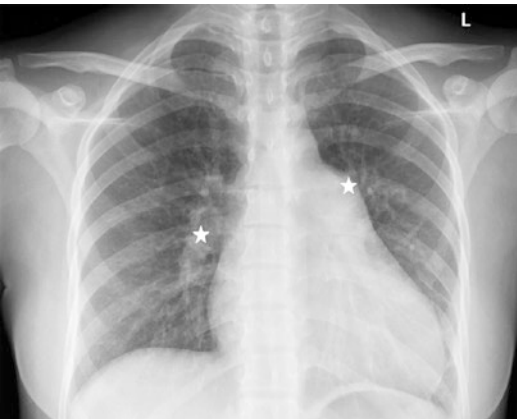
Pulmonary hypertension in a 29-year-old woman with 27 weeks of pregnancy. Chest radiograph reveals dilated pulmonary arteries (stars), and right atrium and right ventricle enlargement
